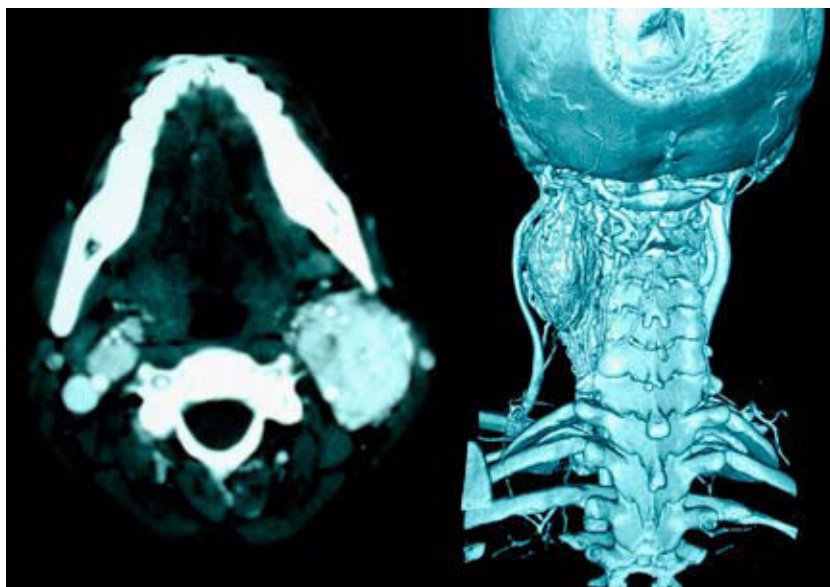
Computed tomography scan: axial cut and three-dimensional reconstruction, clearly showing bilateral cervical tumours at the level of the carotid bifurcation, which capture the contrast media intensely, compatible with bilateral carotid paraganglioma.
